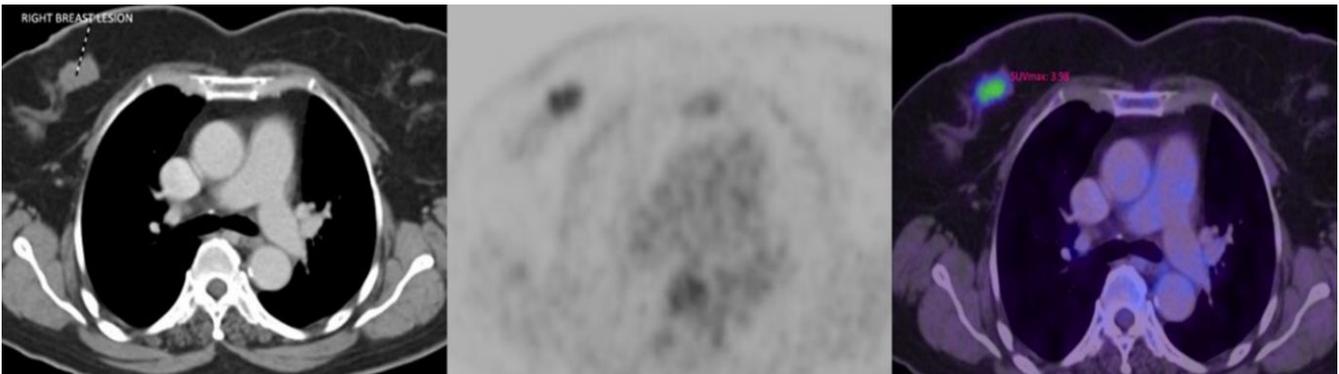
CT(1a), PET(1b), and fusion(1c) images with SUV max uptake of 3.98 in the right breast lesion.
